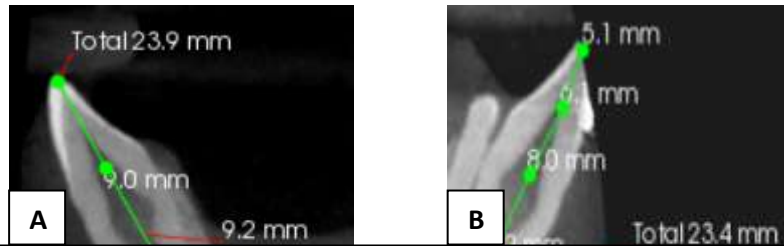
(A) Pre-treatment and (B) Post-retraction CBCT of patient treated with Segmental T-loop
